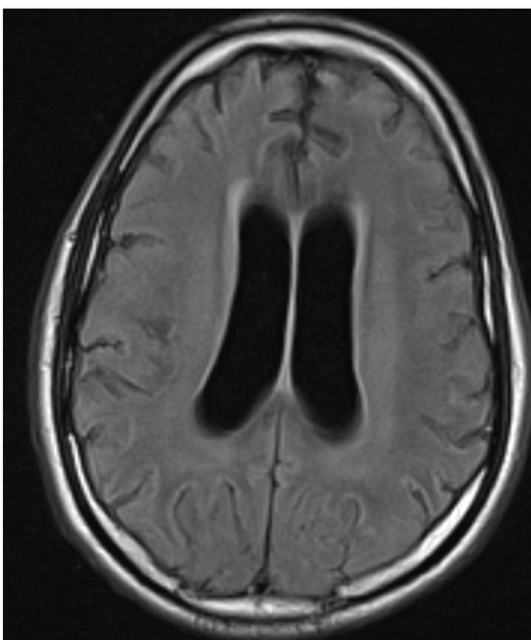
Initial axial brain MRI scan at 1 month.
